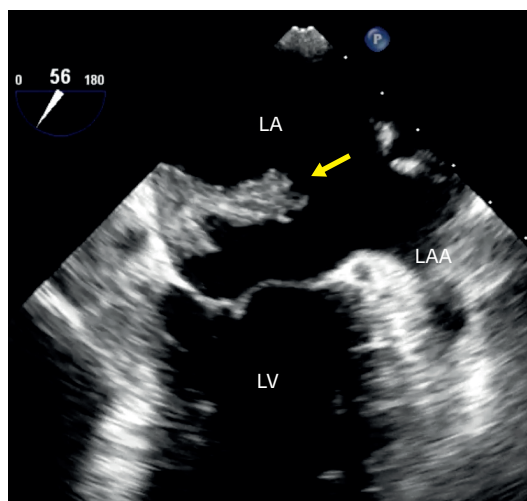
Transesophageal echocardiogram (midesophageal 2 chamber view). Large and very mobile mass, non-pedicated with a large, 1.4-cm base, located just above the mitral annulus. During atrial systole, this mass exhibited slight protrusion into the mitral valve, not exceeding the valvular coaptation plan, causing no obstruction nor significant regurgitation. LA: left atrium, LAA: left atrium appendage, LV: left ventricle.
